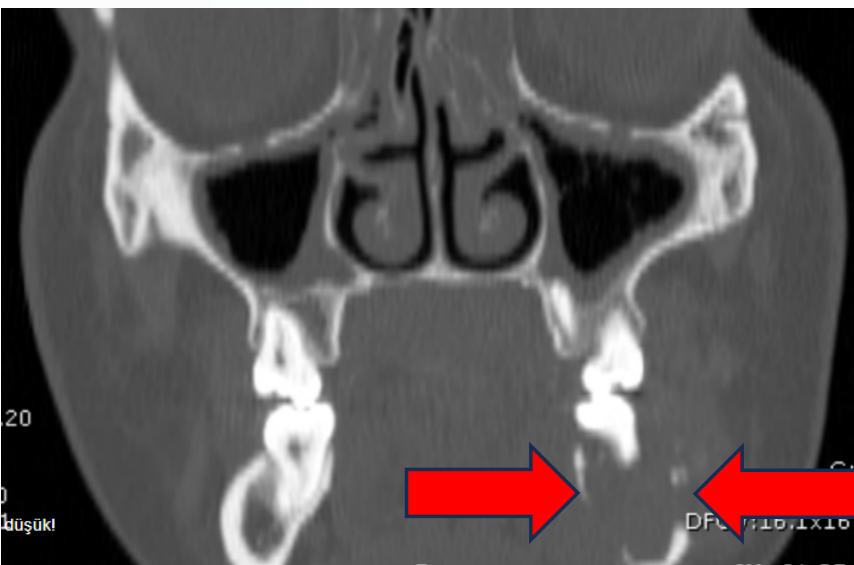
Perforations in the buccal and lingual cortical walls of the left side of the mandible in computed tomography.
